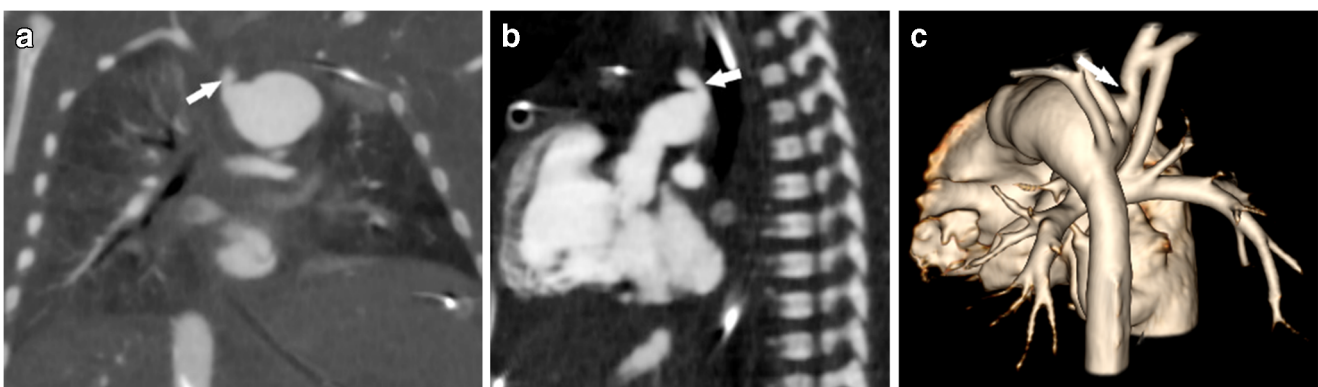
A 1-month-old girl with brachiocephalic trunk narrowing. a–c Coronal (a), sagittal (b) and three-dimensional rendered (c) cardiac CT angiography images show moderate focal narrowing of the brachiocephalic trunk near its origin (*arrows*) as a result of acute
